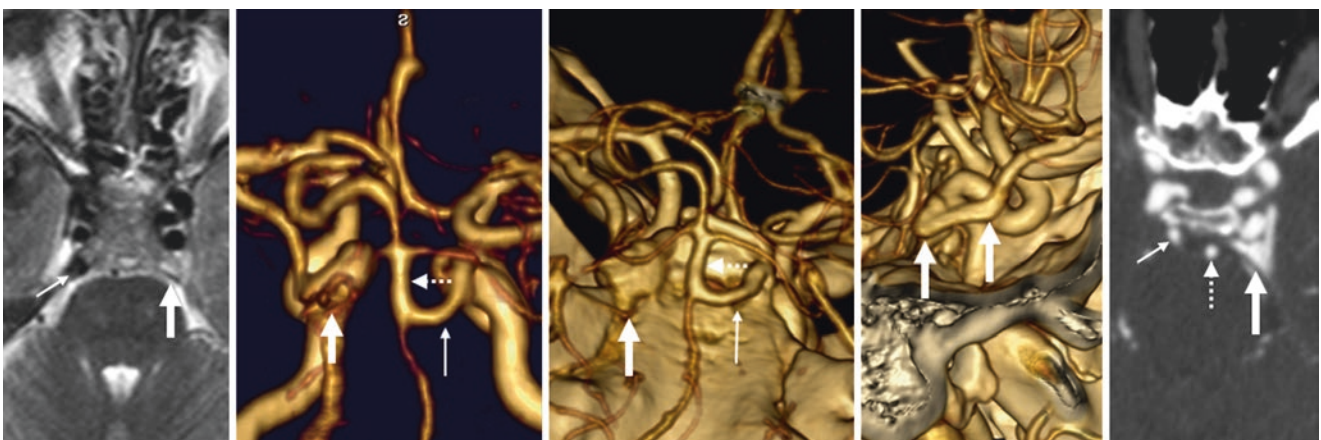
In this 29-year-old, a T2WI (left) shows a flow void (thin arrows) from a persistent trigeminal artery that connects the cavernous right ICA to the basilar (dotted arrows). On PA views from CEMRA (left middle) and CTA (middle), there is a prominent, left-sided vascular
